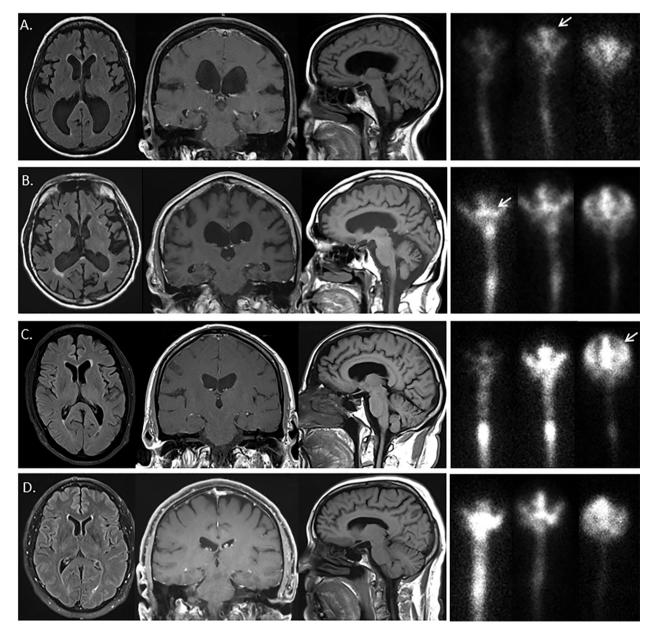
Representative cases. Images from four patients, shown from left to right: axial T2 FLAIR at the level of the lateral and third ventricles, coronal T1 postcontrast or T2 FLAIR at the level of the posterior commissure, sagittal T1-*weighted* images off midline, and anterior projection cisternogram views of the head and upper spinal canal at 2, 4, and 24 h. (A.) 65-year-old man with DESH. Radiotracer was at the basal cisterns at 2 h, lateral ventricles at 4 h (arrow, A) and did not ascend over the convexity at 24 h. (B.) 78-year-old man with ventriculomegaly but no HCTS. Radiotracer was at the basal cisterns at 2 h (arrow, B), lateral ventricles at 4 h, and ascended over convexity at 24 h. (C.) 70-year-old man with HCTS alone. Radiotracer was at the basal cisterns at 2 and 4 h, transiently entered the lateral ventricles at 6 h (not shown), and ascended over the convexity at 24 h (arrow, C). (D.) 63-year-old man with neither ventriculomegaly nor HCTS. Radiotracer was in the basal cisterns at 2 h, unchanged at 4 h, and ascended over convexity at 24 h; radiotracer did not enter the lateral ventricles.
